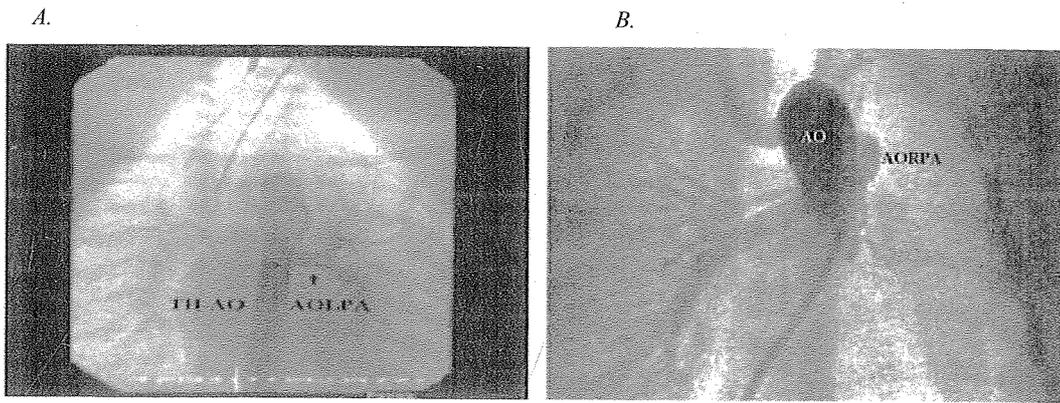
A. Anomalous origin of the left pulmonary artery from the ascending aorta in patient 6. B. Echocardiographic view demonstrating the anomalous origin of the left pulmonary artery in patient 3.
